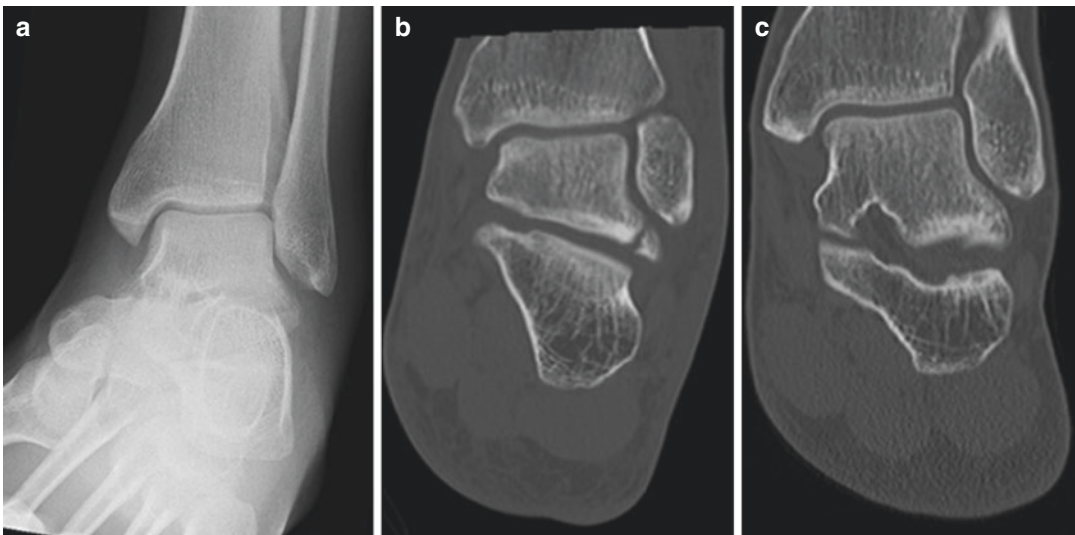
A 30-year-old male with a lateral talar process fracture (a). The CT scan showed a Hawkins type I fracture with 3 mm displacement (b). Despite the advice to perform open reduction and internal fixation, the patient chose a conservative treatment. Immobilization in a short-leg, non-weight-bearing cast for a period of 6 weeks was
